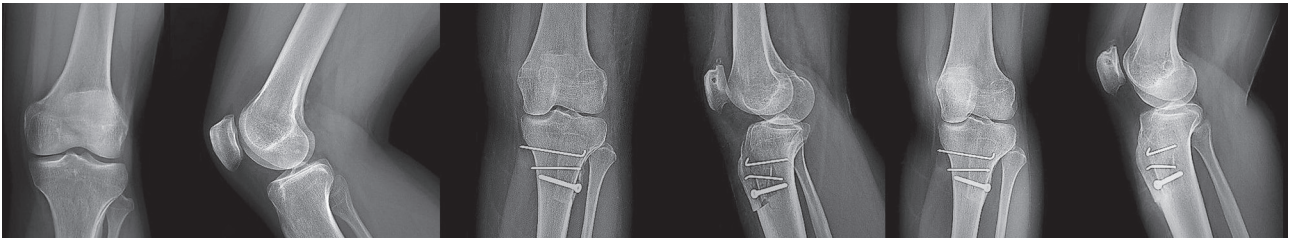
Radiographic findings of the knee joint of the patient D., 31 years old, before and after surgery and 1-year follow-up
